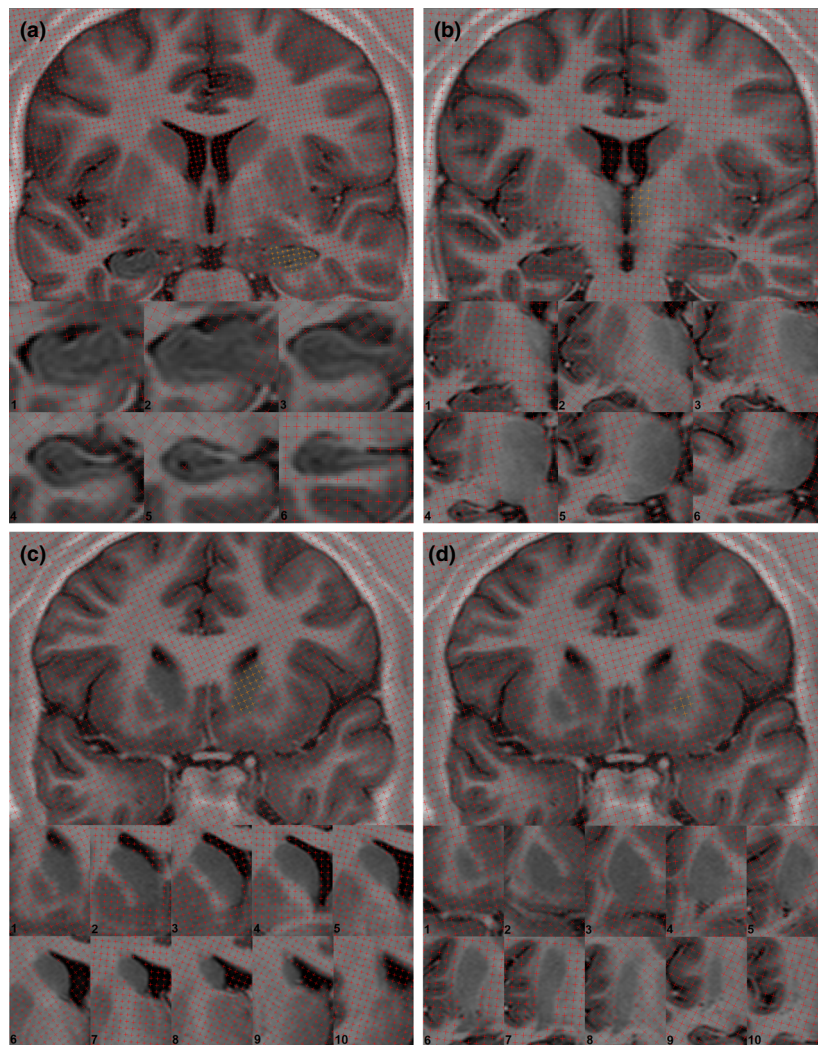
T1-weighted fluid attenuated inversion recovery coronal sections through an exemplar patient showing point counting for stereology through the subcortical volumes of interest. For each structure, point counts are removed in the left hemisphere and coloured orange in the right hemisphere. (A) hippocampus. (B) thalamus. (C) Caudate nucleus. (D) Putamen. Zoomed sections at the bottom of each panel show point counting in a rostral (top left) to caudal (bottom right) direction.
